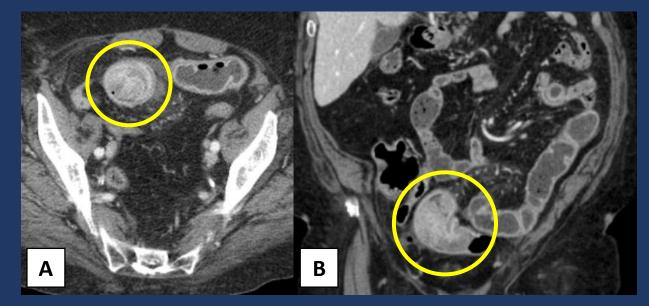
Axial (A) and coronal (B) CT images of a patient with history of melanoma, showing an endoluminal mass with heterogeneous enhancing (circle), causing slight distension of the upstream loops, suspected of metastatic lesion that was confirmed after surgery.
